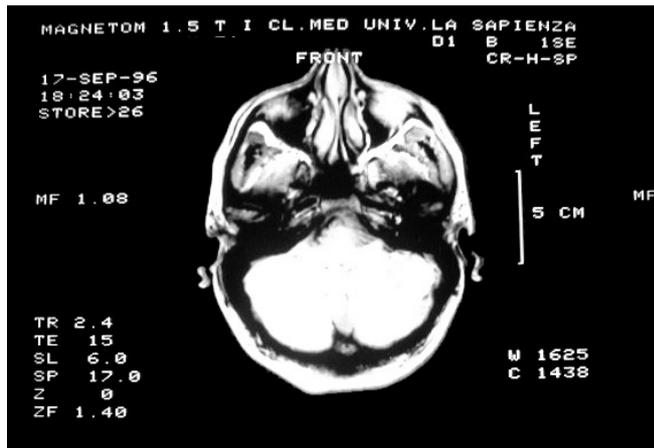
Normal signal intensity of cerebral MRI sequence in HIV patient with varicella zoster virus (VZV) infection
